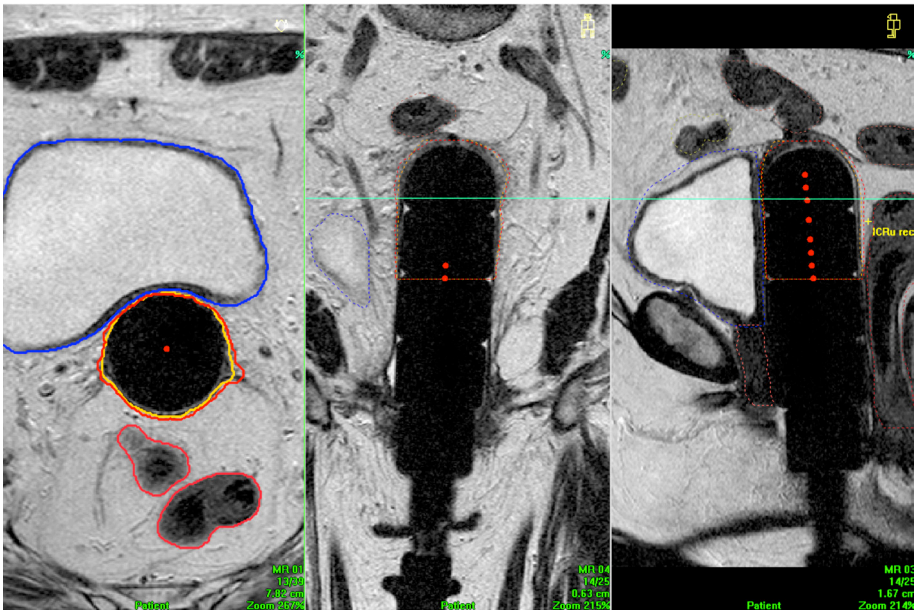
Axial, coronal and sagittal MRI scan of vaginal brachytherapy cylinder in treatment position. A clinical target volume was contoured by two observers (red, orange), organs at risk by one (bladder in blue, rectum in brown).
